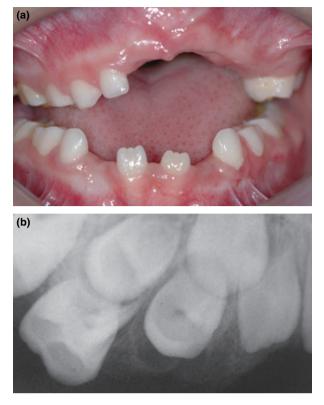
(a,b) Clinical and radiographic controls realized after 30 days.
